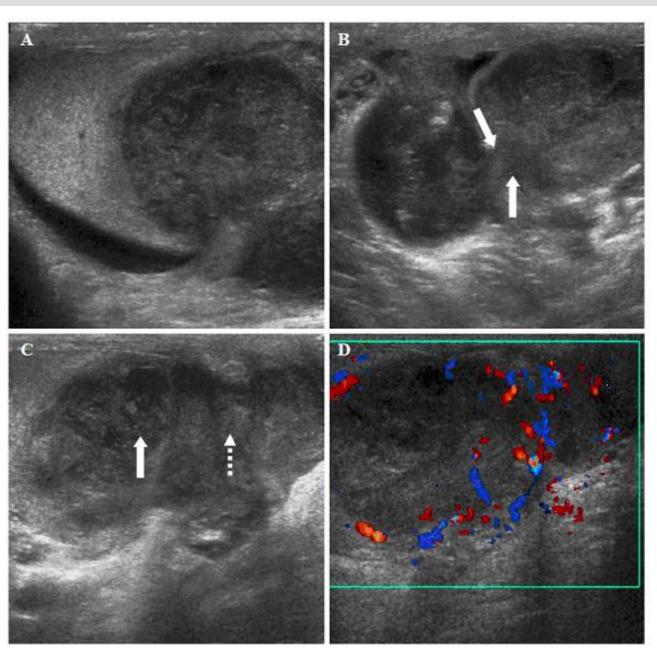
76-year-old male with left tuberculous epididymo-orchitis. Sonographic views of the left testicle, including Doppler ultrasound. A Longitudinal image shows a heterogeneous mass in the inferior portion of the testicle; B transverse image of the lower testicle shows continuity (white arrow) of the testicular lesion (right side) with an extra-testicular lesion medially; C longitudinal image demonstrates extension of the epididymal mass (dotted arrow) into the lower pole of the testicle (white arrow); D Doppler ultrasound of the testicle and epididymis shows internal hypovascularity and peripheral increased flow. (All images obtained with a 12 MHz linear transducer)
